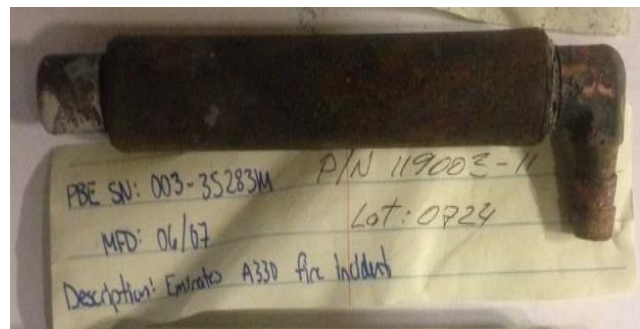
The candle from the PBE unit involved in the Incident [Source: B/E Aerospace CT scan report]
